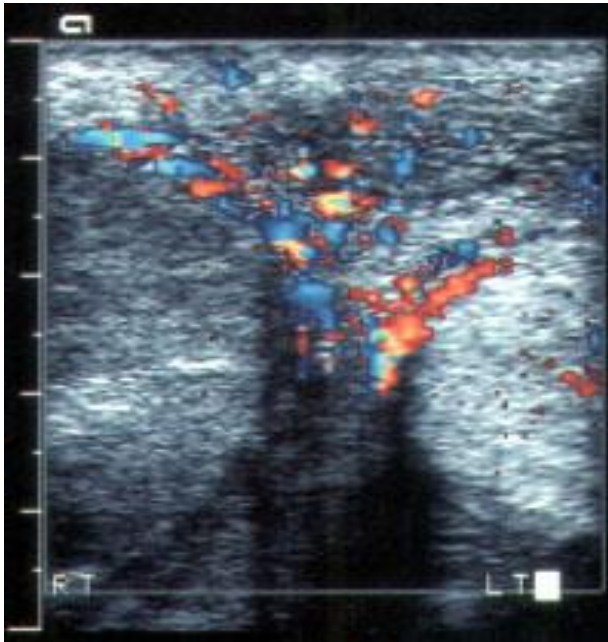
Color Doppler ultrasonogram showing late torsion affecting the right testis in a 16-year-old boy who had pain for 24 hours. Note increased blood flow around the right testis but absence of flow within the substance of the testis.
